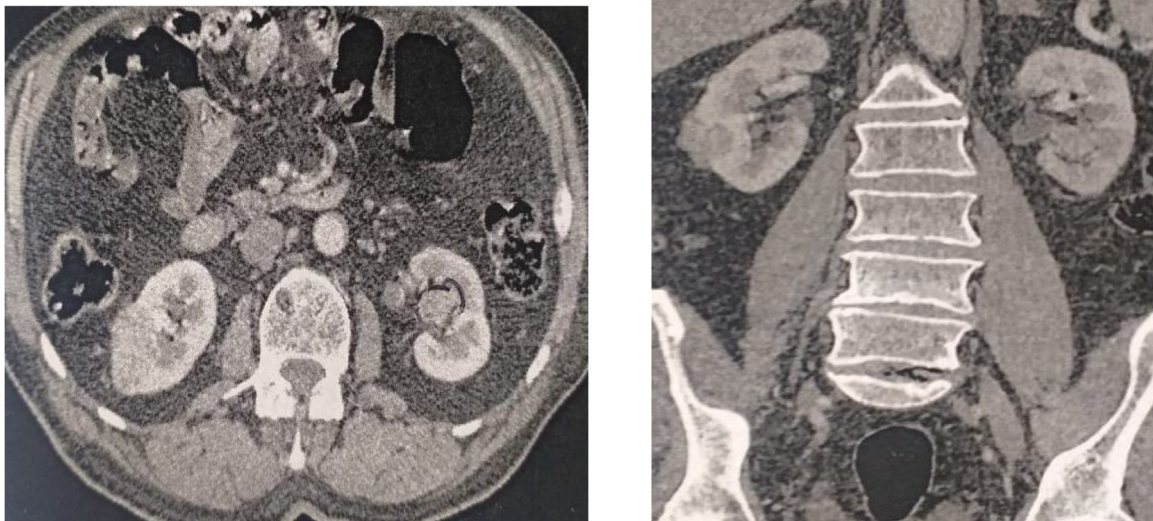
Axial and coronal computed tomography image reveals a process of the excretory tract in the left renal and a lower right polar renal lesion.
